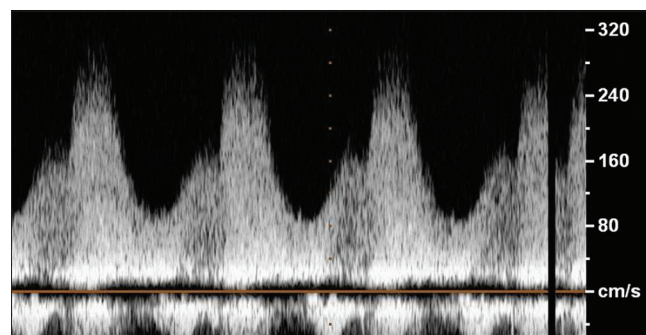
Spectral Doppler in the ductus arteriosus at 36 weeks gestation after 1 month of maternal hyperoxygenation demonstrating moderate ductus arteriosus restriction, with a peak instantaneous gradient of 35 mmHg
